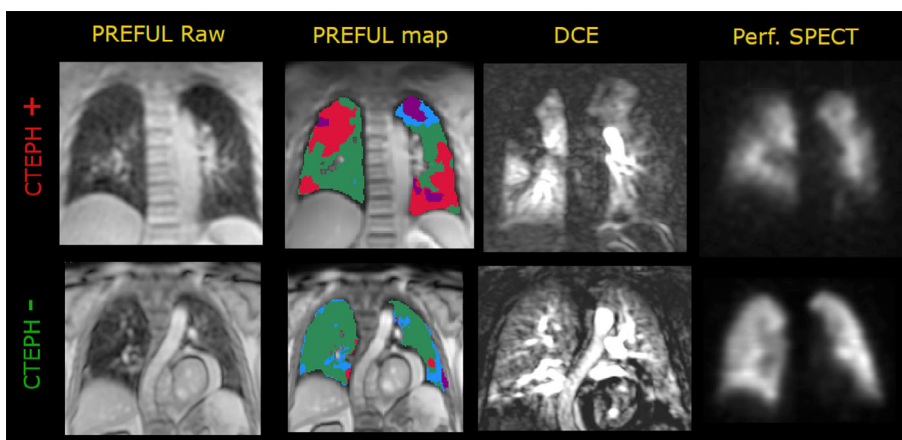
Representative MRI and perfusion SPECT slices from a positive and a negative CTEPH patients (scanned at site 04—Sheffield and site 08—Zurich, respectively). Colored PREFUL maps show perfusion defects in red, ventilation defects in blue, and matched defects in violet.
